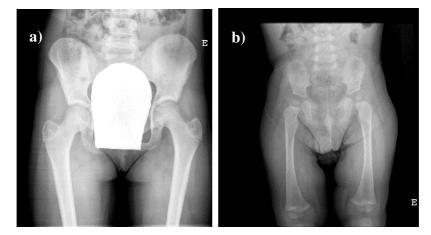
Examples of incorrect placement and inappropriate size of gonad shield in a female patient (a) and of inappropriate* x-ray beam limitation and field size *(b).*
